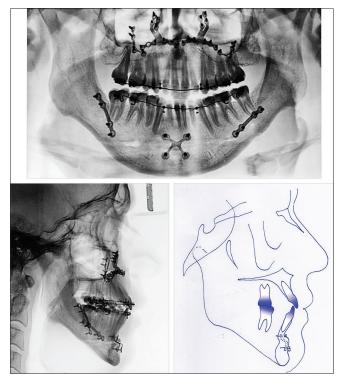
Progress panoramic, cephalometric radiographs, tracing photo, and maxillo-mandibular fixation view 45 days after orthognathic surgery
